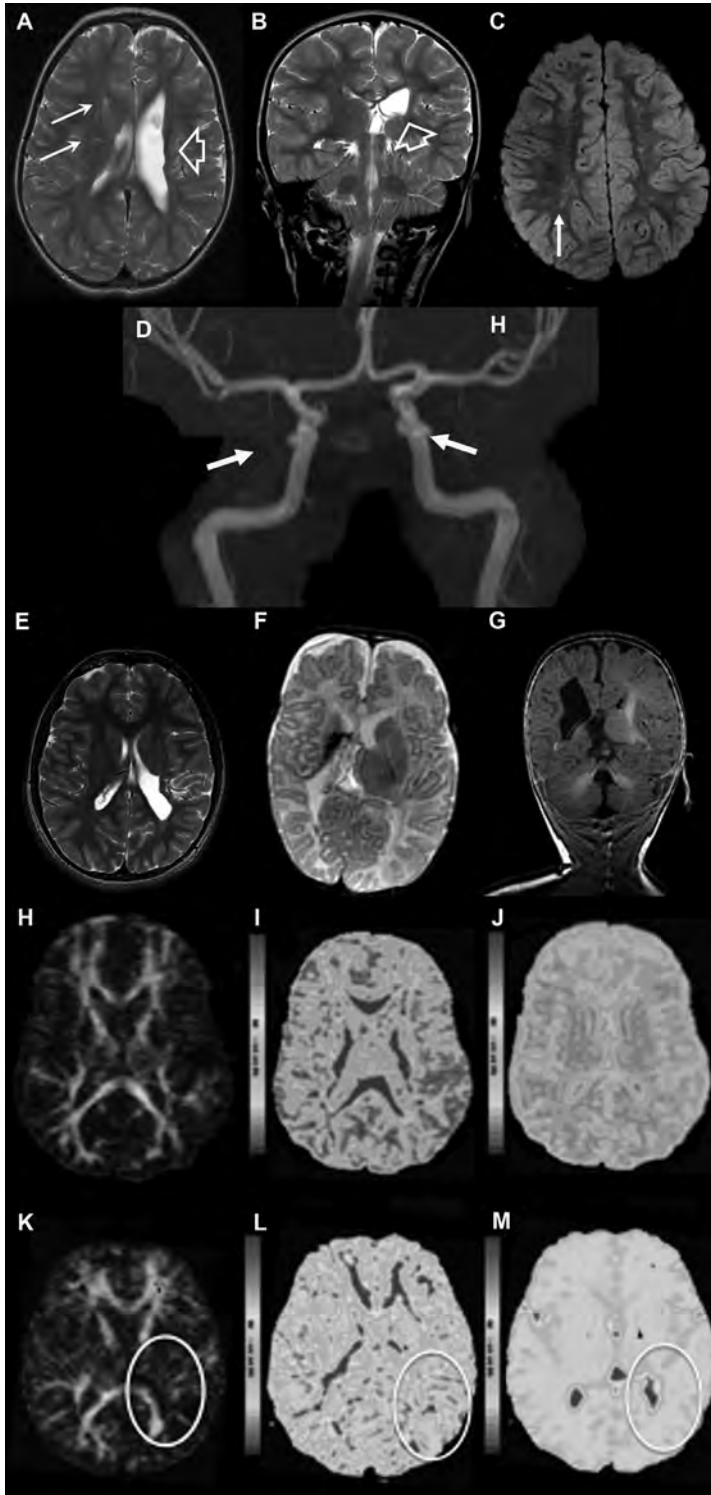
Brain MRI of patients with *COL4A2* mutations.
